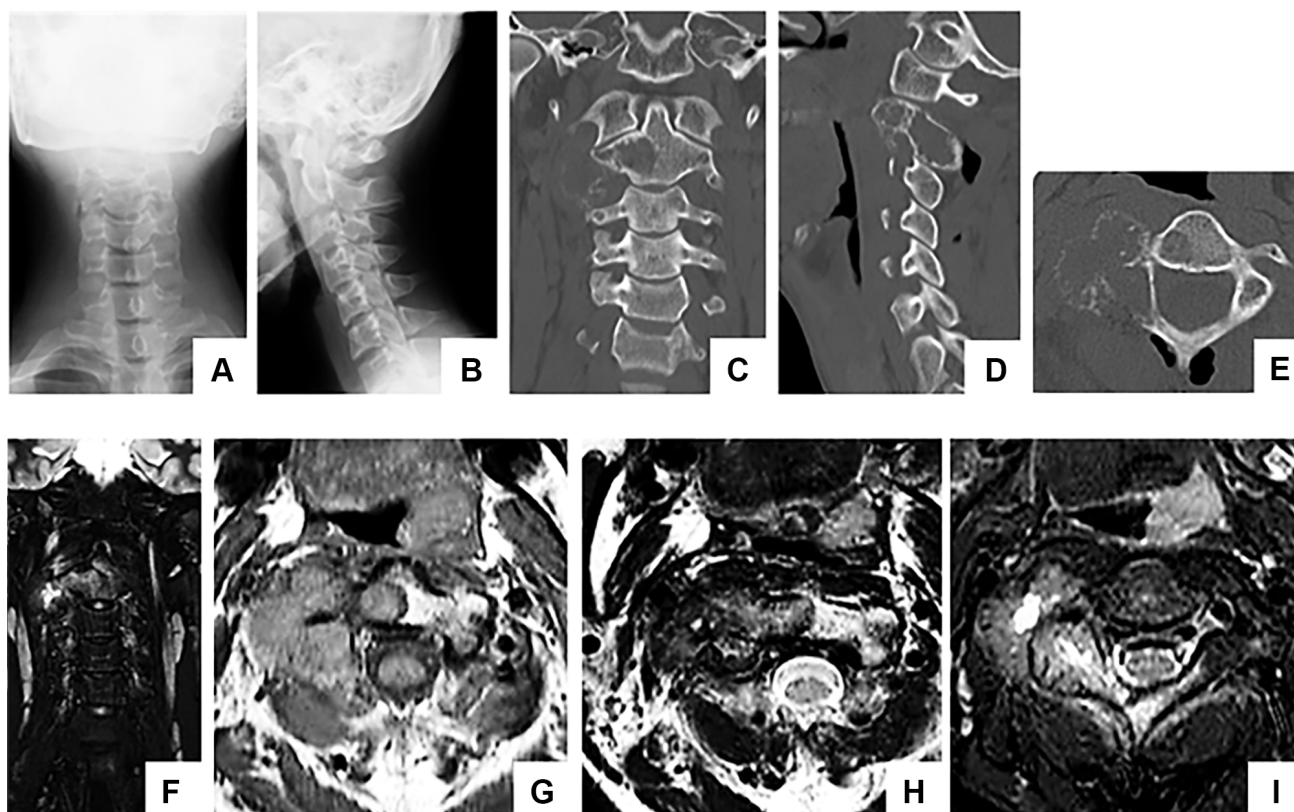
Preoperative imaging findings. A, B, C, D, E) X-ray and computed tomography (CT) images showing bone lucency with surrounding bone sclerosis on the right side of the C2 vertebral body. F, G, H, I) Magnetic resonance imaging shows T1, T2 iso and STIR high-signal images, and as in CT, mass image from the right side of the C2 vertebral body to extra vertebrae.
